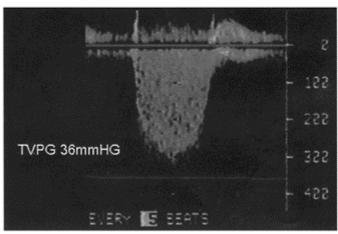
Disturbed pulmonary ejection assessed with PW Doppler in right ventricular outflow tract. (A) Markedly shortened acceleration time (AcT) of 45 ms with midsystolic notch (notch) in a patient with massive acute PE but only (B) moderately elevated tricuspid valve peak systolic gradient (below 60 mmHg). An example of the '60/60 sign' (see text).
